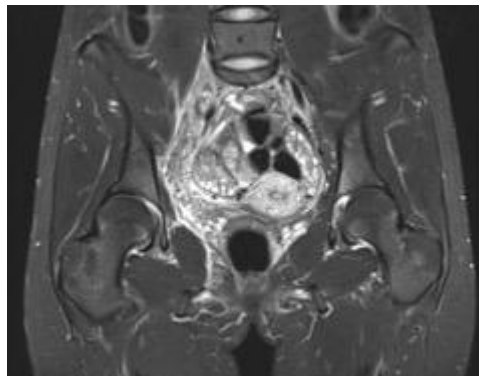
MRI pelvis without contrast demonstrating focal bone marrow edema of the sacral aspect of the right sacroiliac joint, mild hyperintense intrasubstance edema involving the proximal to mid right piriformis and the right mid gluteus maximus muscle, and mildly increased signal at the insertion of the bilateral hamstrings suggestive of tendinosis.
